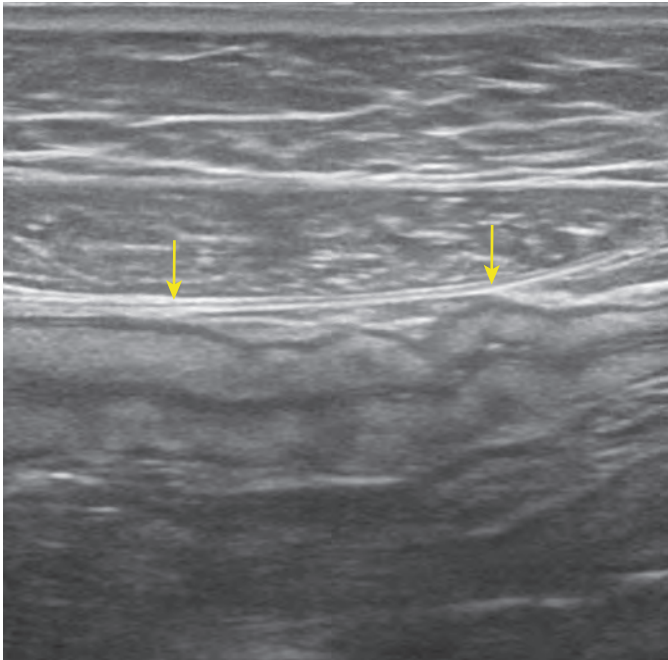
Chronic ulcerative colitis: sonographic findings. The descending colon, imaged longitudinally, shows circumferential mural thickening (arrows).
